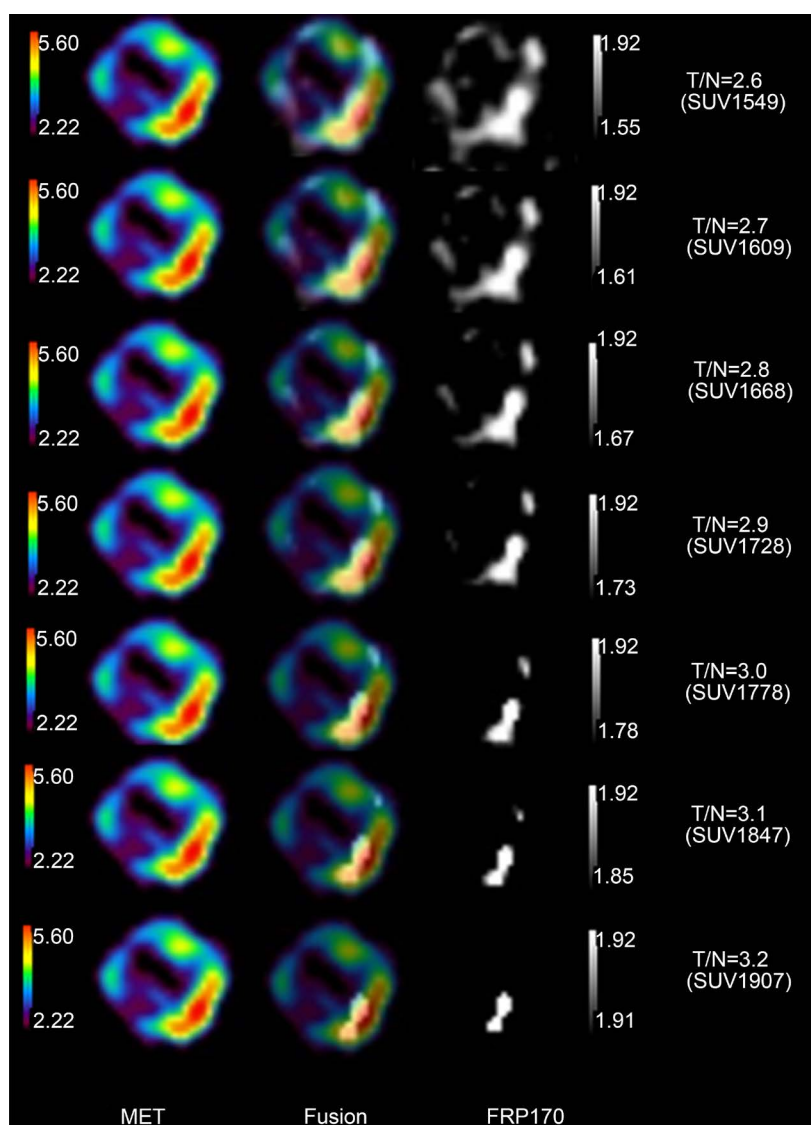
Representative fusion imaging superimposing pixels extracted from FRP170 PET on those extracted from MET PET in Case 4. Left, pixels extracted from MET; middle, fusion imaging; right, pixels extracted from FRP170. T/N and SUV values show the lower limit in the extraction range.
